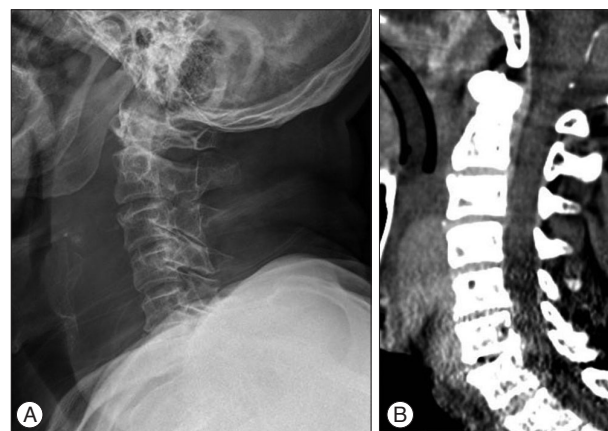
A : A lateral X-ray image of a 78-year-old male patient showing widening of the prevertebral space. B : CT angiography showed prevertebral hematoma and a dark air density region at the C6-7 disc.
